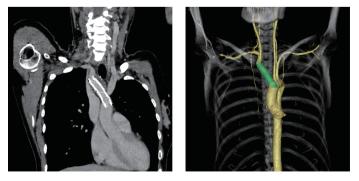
Images of computed tomography scan after treatment
